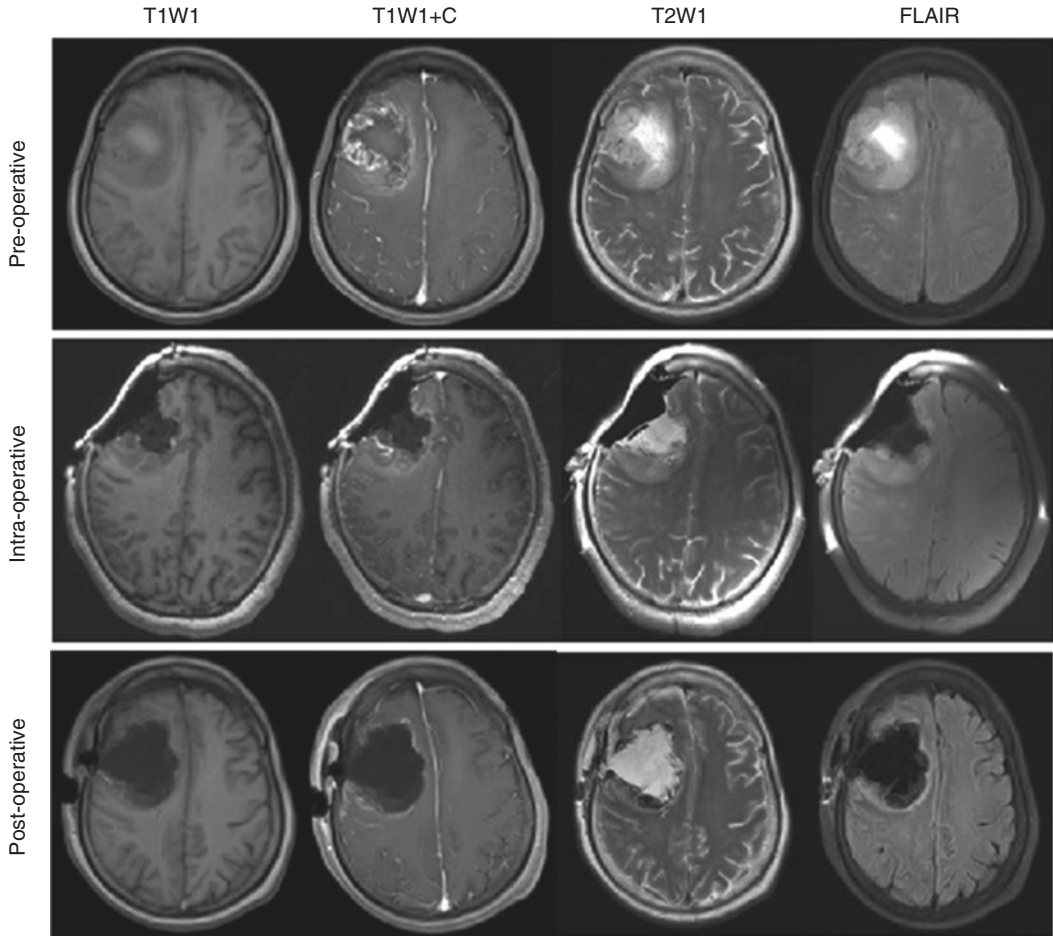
A 70-year-old female patient admitted with memory loss for >7 months; postoperative pathological diagnosis: glioblastoma, WHO grade IV. The pre-operative MRI shows a right frontal lobe tumor. The patient's pre-operative imaging was used in pre-surgical
